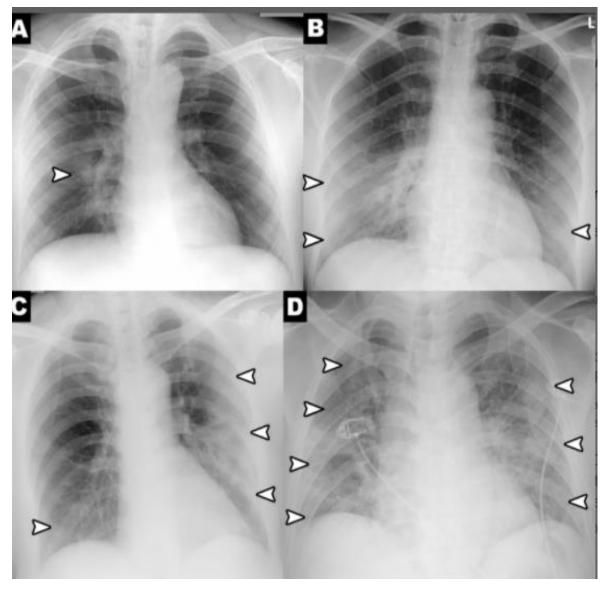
Examples of the modified radiographic assessment of lung oedema (10)
